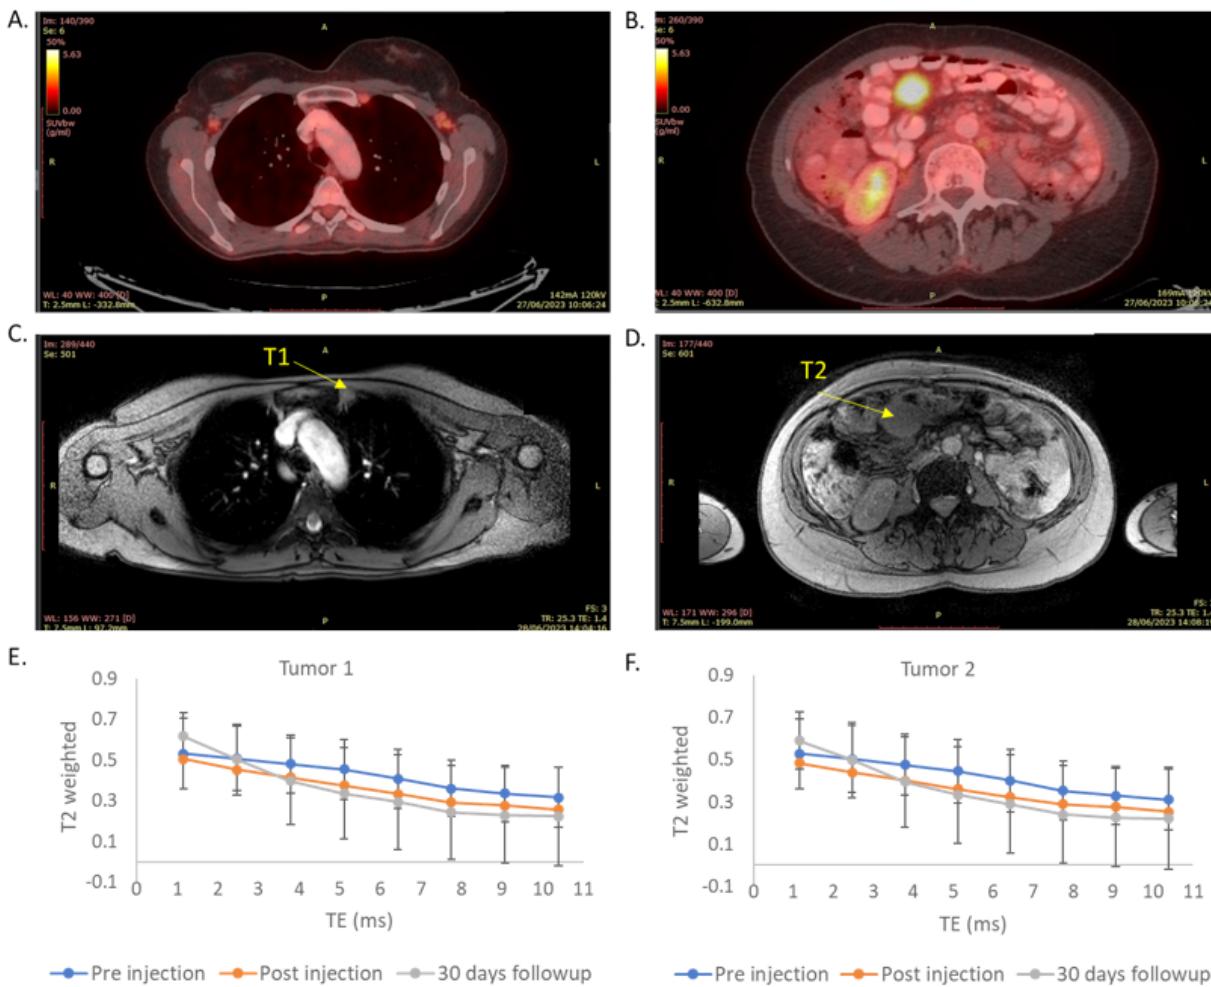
MRI analysis of SaNP accumulation and clearance in and from tumors. Tumors T1 (A, C, E) and T2 (B, D, F). Images from PET-CT scan (A-B), images from MRI scans obtained using a T2* scanning mode (C-D). Yellow arrows indicate tumor locations. T2-weighed signals of tumor T1 (E) and tumor T2 (F).
